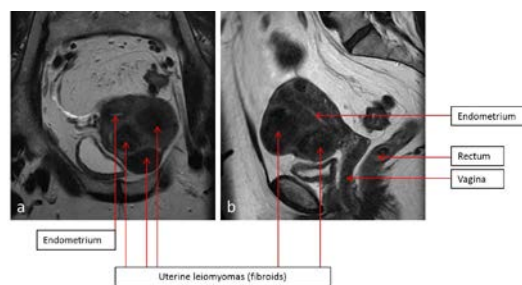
49-year-old female patient with history of uterine fibroids. Coronal plane (a) and sagittal plane (b) images from pelvic MRI, demonstrate multiple uterine fibroids that were stable over four years. Courtesy of University of Massachusetts Medical School, Abdominal Imaging Division, UMass Memorial Medical Center.
